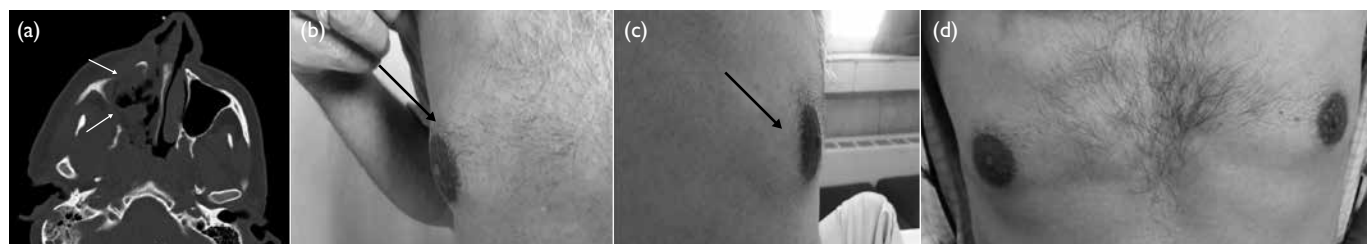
(a) Axial paranasal computed tomography image revealed right maxillary sinus involvement with bone destruction (arrows). Clinical photographs demonstrating (b) right-sided and (c) left-sided gynaecomastia (arrows). (d) Resolution of bilateral breast enlargement 4 weeks after discontinuation of posaconazole
